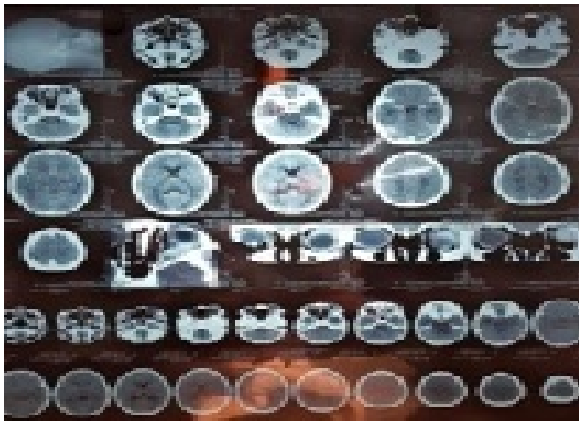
CT Scan showing enhancement of lateral rectus muscle with mild enhancement. Small ring-enhancing hypodense area measuring 9.5*8.4mm seen in the posterior aspect of the left lateral rectus muscle.
